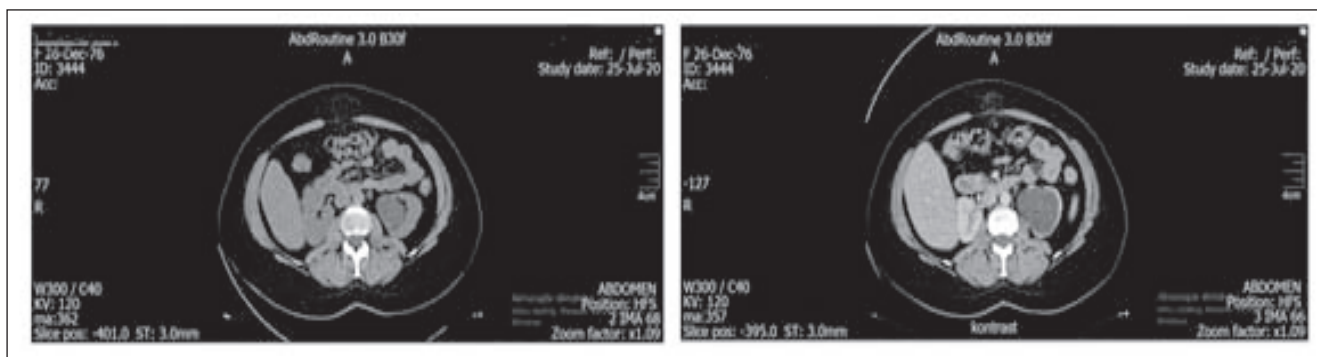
Computed tomography scan of the tumor in left kidney.
